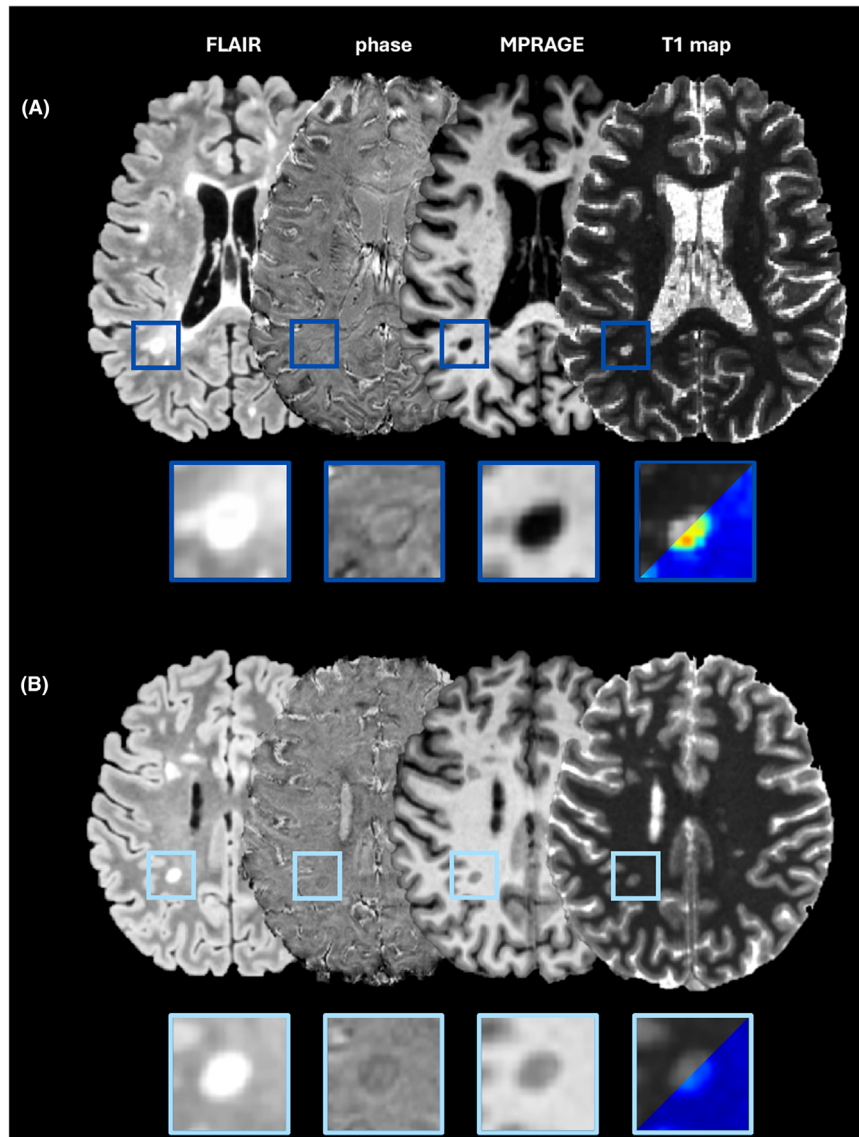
The importance of long-T1 PRL in clinical and MRI metrics. (A) MR images of a 24-year-old RRMS male patient with EDSS of 6 and MSSS of 9.46. The majority of PRL show long-T1 values (dark blue boxes). (B) MR images of a 26-year-old RRMS female patient with EDSS of 2 and MSSS of 5.58. Based on the calculated T1 cutoff, all the detected PRL are considered short-T1 PRL. EDSS, Expanded Disability Status Scale; MSSS, Multiple Sclerosis Severity Score; PRL, paramagnetic rim lesions; RRMS, relapsing–remitting MS.
